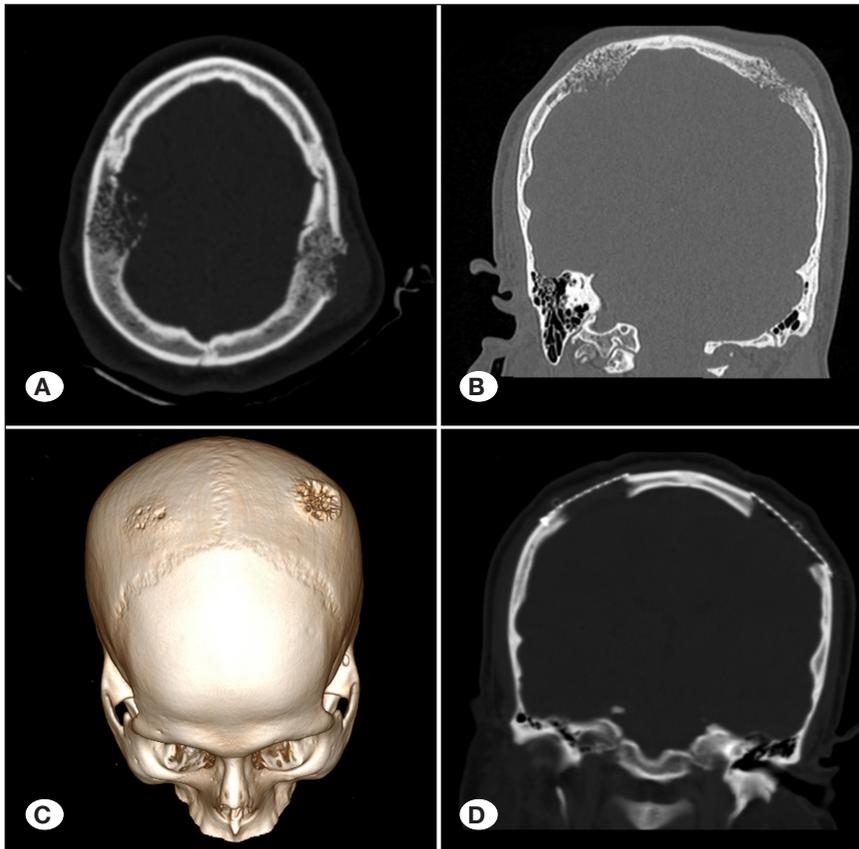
Pre-operative cranial sagittal (A) and coronal (B) CT scans showing giant intraosseous meningeal meningioma causing diffuse sclerosis with bone expansion in left parietal bone. (C) Pre-operative 3D-CT reconstruction of the mass lesion. (D) Post-operative coronal CT scan displaying total excision of the lesion.
